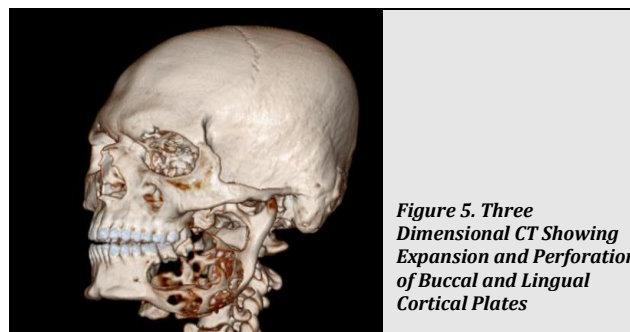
Three Dimensional CT Showing Expansion and Perforation of Buccal and Lingual Cortical Plates
